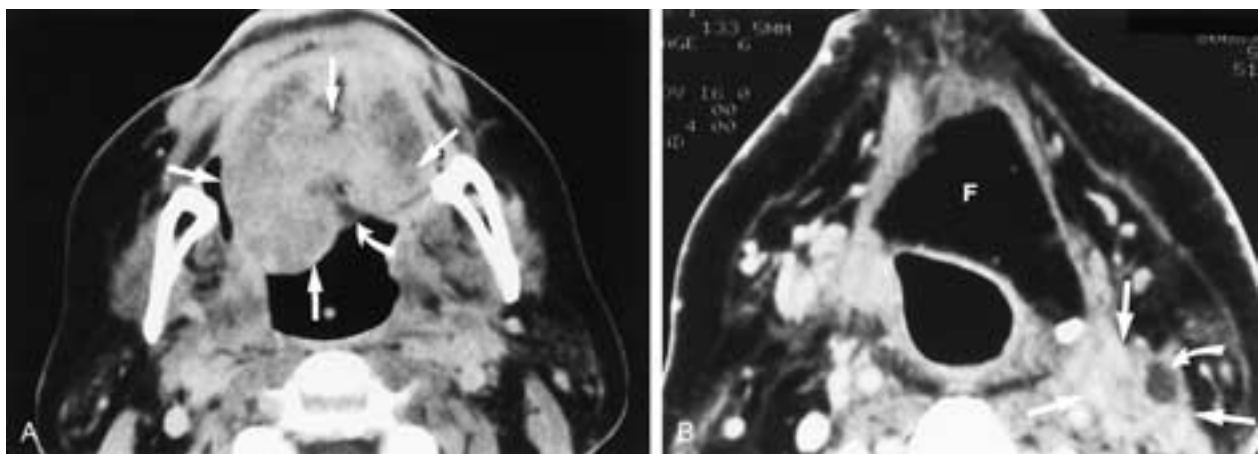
A, Axial CT scan obtained through the tongue base shows a large, ulcerated mass invading and replacing the tongue base (straight arrows, tumor; curved arrow, ulceration). B, This patient underwent a total glossectomy and myocutaneous flap reconstruction. The flap (F) fills in the operative defect and provides a mucosal surface to the pharynx. Note the low-attenuation lymph node (curved arrow) and the surrounding soft-tissue mass (straight arrows) indicating recurrent disease.
